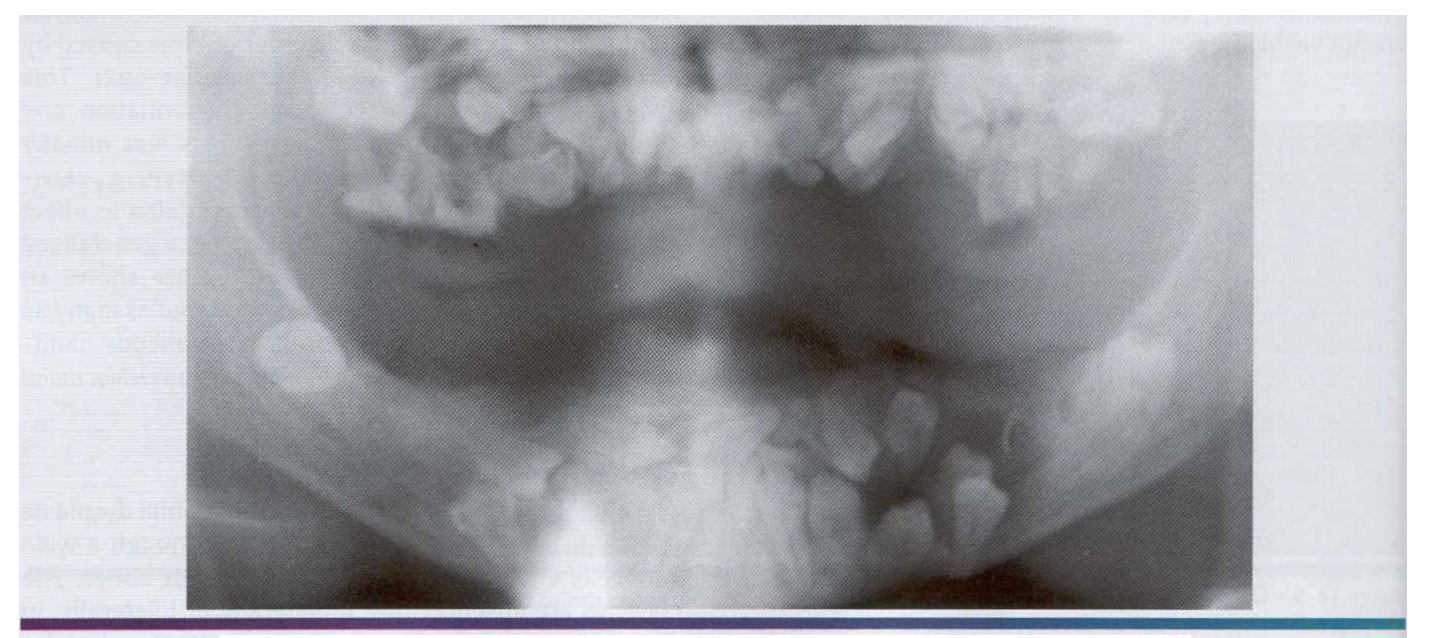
• Cleidocranial dysplasia. Panoramic radiograph showing multiple unerupted teeth. (Courtesy of Dr. John R. Cramer.)
